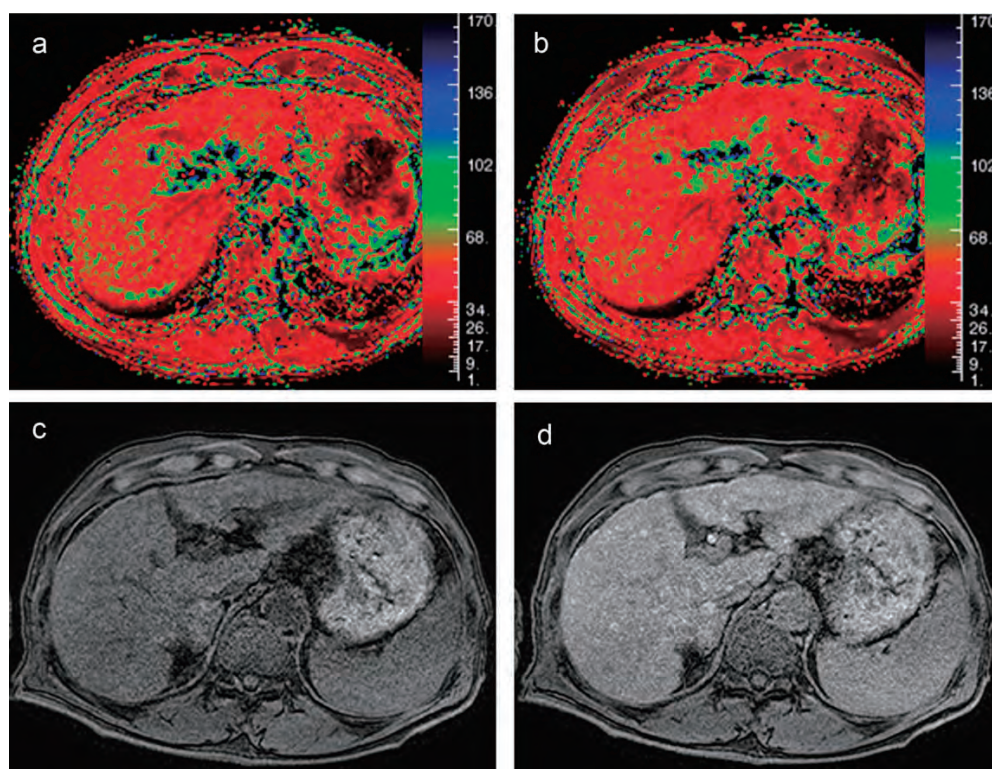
Hepatic cirrhosis (Child-Pugh B) in a 69-year-old man. Mean T2* values of the liver on pre- and post-contrast imaging at 18 min were 49.8 ms and 49.1 ms, respectively. No signal change in the liver was apparent between pre- (a) and post-contrast (b) T2* value mapping images, as the T2* shortening effect of the liver was weaker than that for normal liver function. On pre- (c) and post-contrast (d) fat-suppressed T1-weighted GRE imaging (TR/TE, 2.13/4.31; flip angle, 15°) at 20 min, liver-to-muscle signal intensity ratios were 1.47 and 2.00, respectively. Increase rate was 1.36.
